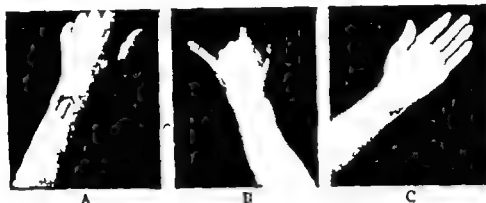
Case W. R. P. X-ray burn. A chip of steel entered the volar surface of forearm. This was removed under a fluoroscope the dorsal surface being toward the ray
